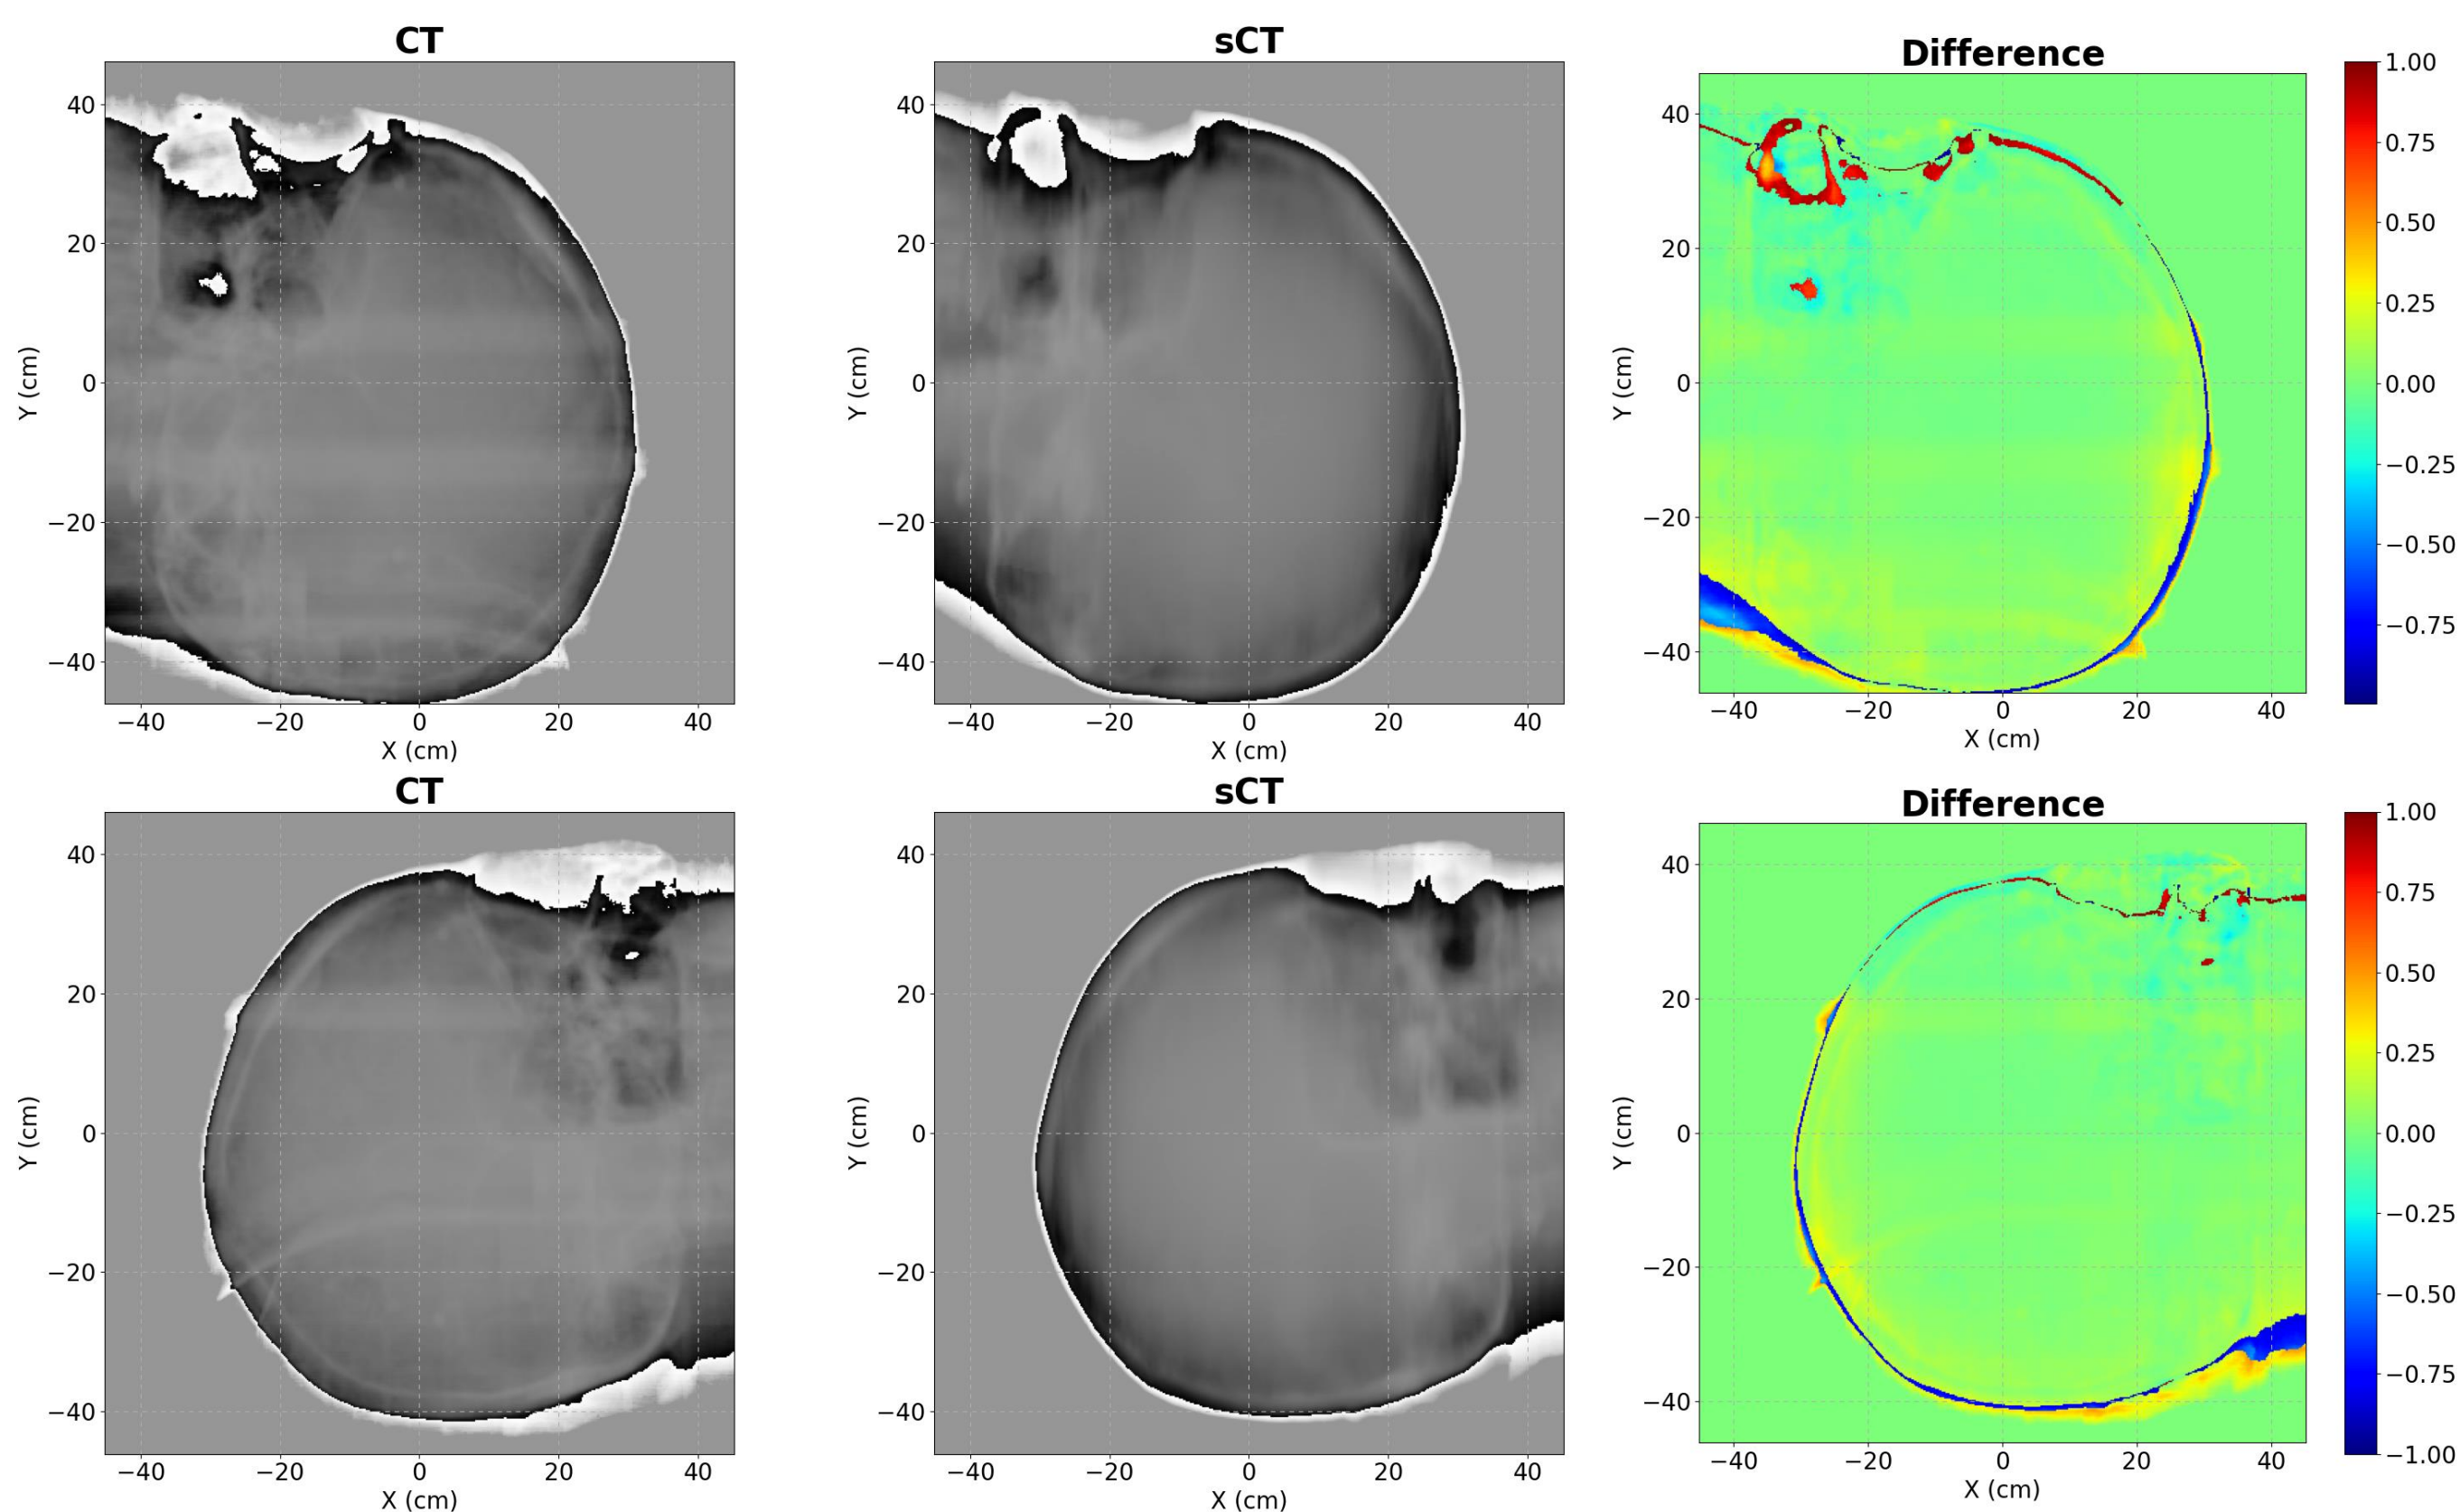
Visual image analysis sample. The top row show the results for Camera A and the bottom row correspond to Camera B. The rightmost column shows a simple difference plot between CT-based and sCT-based DRR images.
